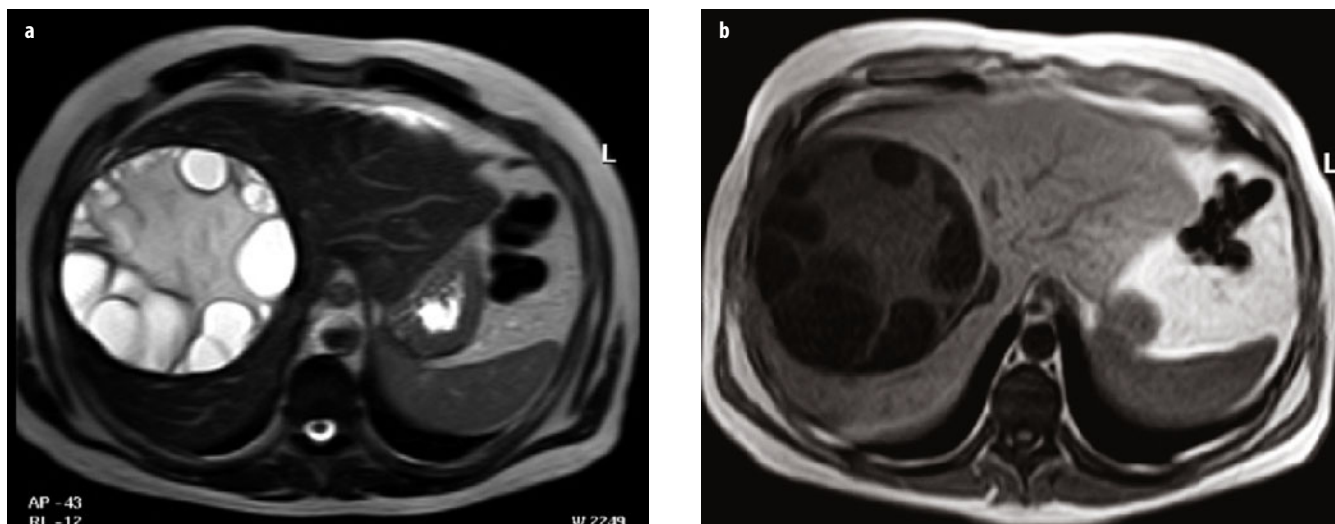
a, b. *Echinococcus granulosus* cyst in a 28-year-old man with right upper quadrant pain. a Axial T2-weighted image demonstrates a large cystic mass in the right lobe of the liver surrounded by a hypointense rim and containing more hyperintense, smaller cysts in its periphery. b On axial T1-weighted image, the hypointense rim is well visualized and the peripheral cysts are hypointense relative to the center of the lesion. Reproduced from Hodler J, von Schulthess GK, Zollkofer ChL (Eds) (2010) *Diseases of the Abdomen and Pelvis* 2010-2013. Springer-Verlag Italia, Milan, pp. 56-60
